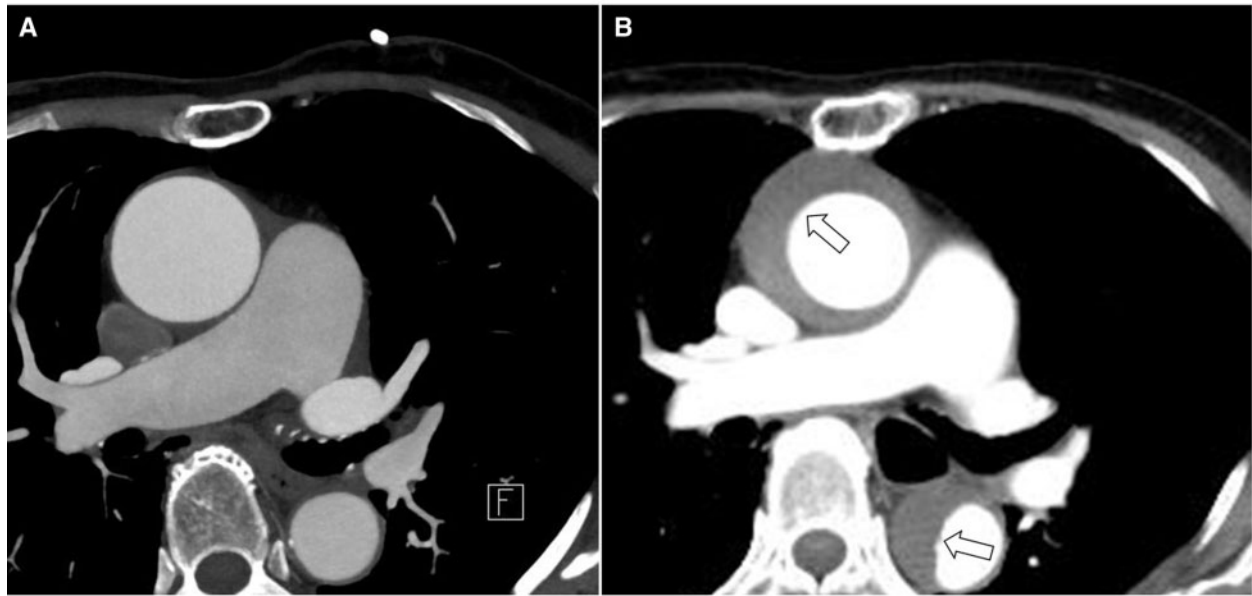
(A) Pre-procedural cardiac computed tomography showed no abnormal finding of the aorta (maximum diameter: 40 mm). (B) Cardiac computed tomography showed Stanford type A aortic dissection (white arrows, maximum diameter: 49 mm) after transoesophageal echocardiography.
